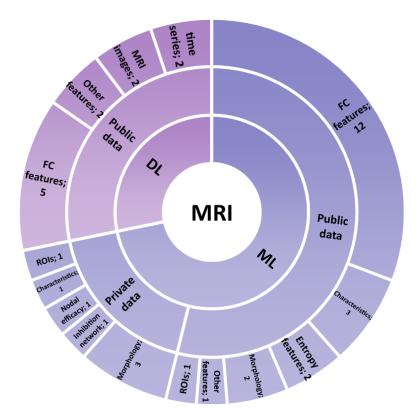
Sunburst plot of AI studies using MRI data. First level indicates type of AI studies, second level indicates type of dataset used, and third level indicates type of features used to train the AI models.
